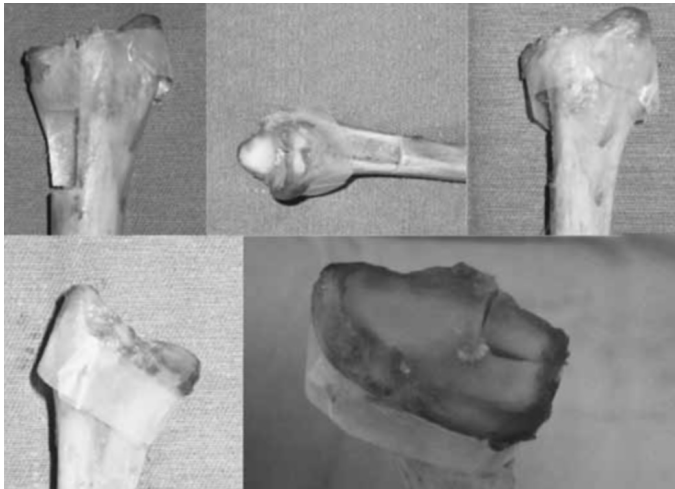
Position of the radius during radiographs in the following views: (A) front; (B) lateral; (C); OSP; (D) OSS; and (E) tangential.
